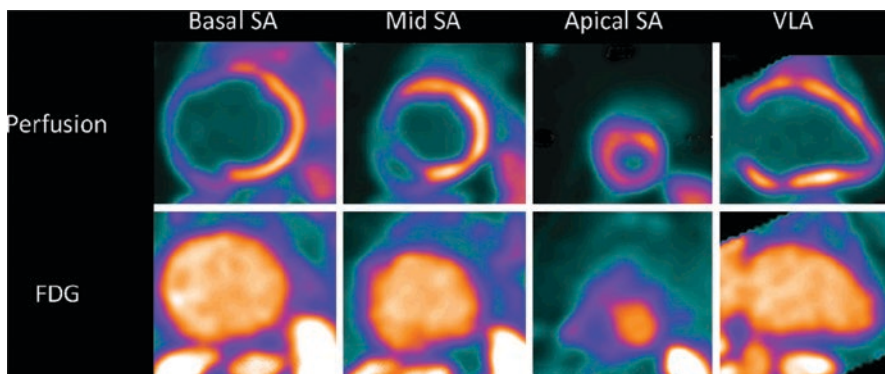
Myocardial FDG-PET of a patient with biopsy-proven giant cell myocarditis “burnt-out” showing a large perfusion defect involving the basal and mid ventricular septal as well as mid ventricular inferior wall with no definitive abnormal FDG uptake
